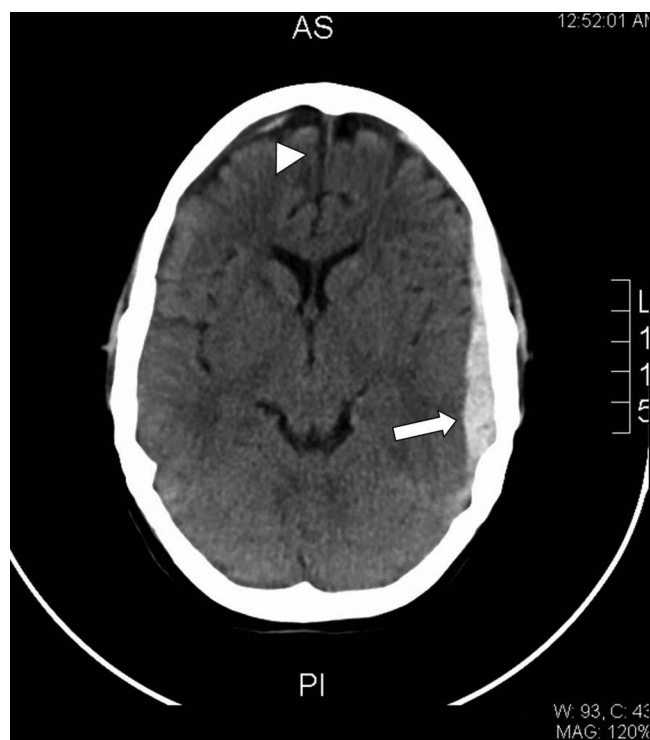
Noncontrast CT of the brain demonstrating a 1.2-cm-thick acute subdural hematoma along the left frontal, parietal, and temporal lobes (arrow) with 2 mm of left-to-right midline shift and a smaller 2-mm right frontal acute subdural hematoma (arrowhead).
